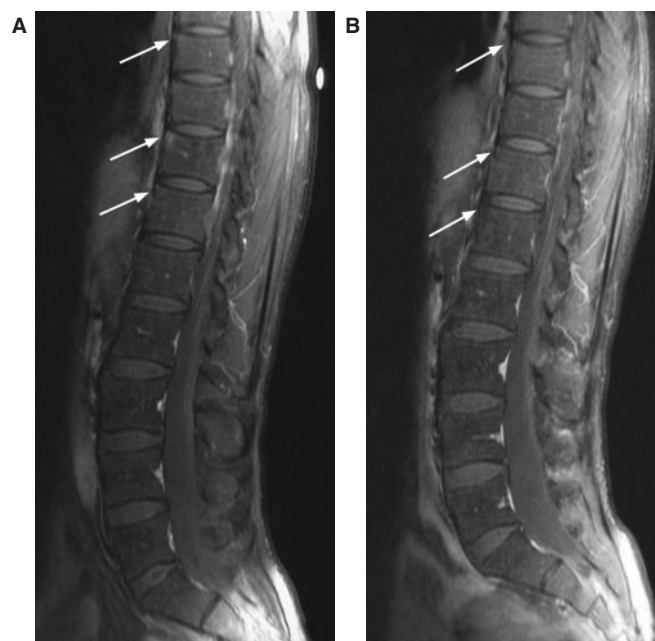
Sagittal T1-weighted fat-suppressed post-contrast MR images of lumbar spine.
